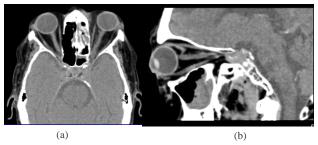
CT Orbit showing increased thickness of optic nerve sheath complex with irregular margins, opacity in ethmoid and maxillary sinus on left side and heterogeneous soft tissue density at orbital apex and cavernous sinus area.
